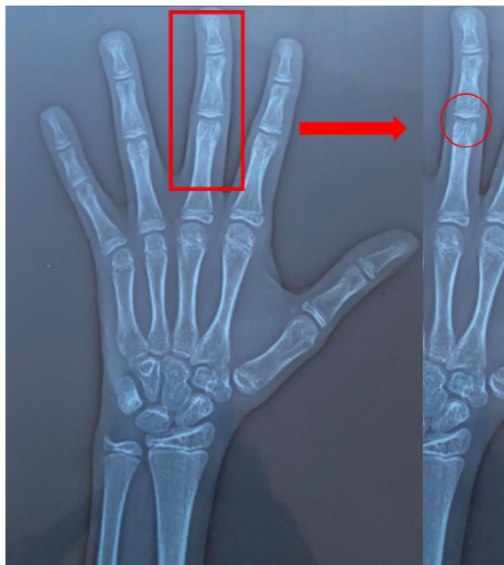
Hand and wrist X-ray.
